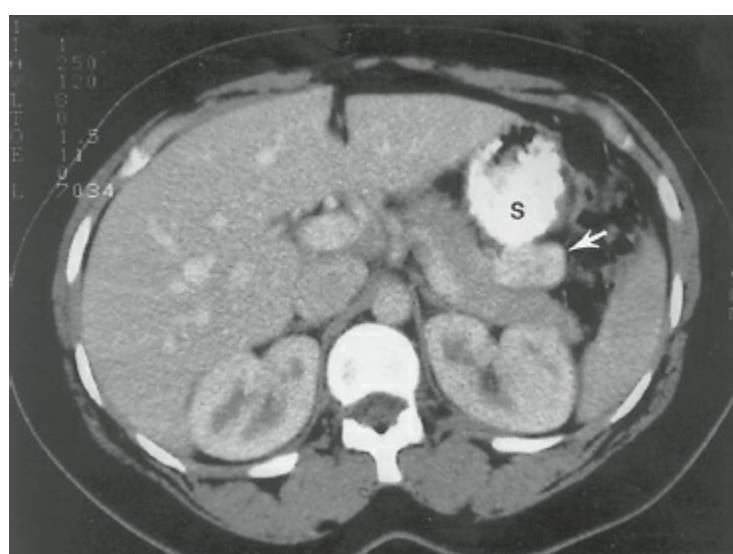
Computed tomography with oral and intravenous contrast in a patient with biochemical evidence of insulinoma. The neoplasm (*arrow*) is seen as a contrast-enhancing structure, 3 cm in diameter, in the tail of the pancreas posterior to the stomach (S). (From Yeo CJ. Islet cell tumors of the pancreas. In: Niederhuber JE, ed. *Current Therapy in Oncology*. St. Louis, MO: Mosby; 1993:272, with permission.)
